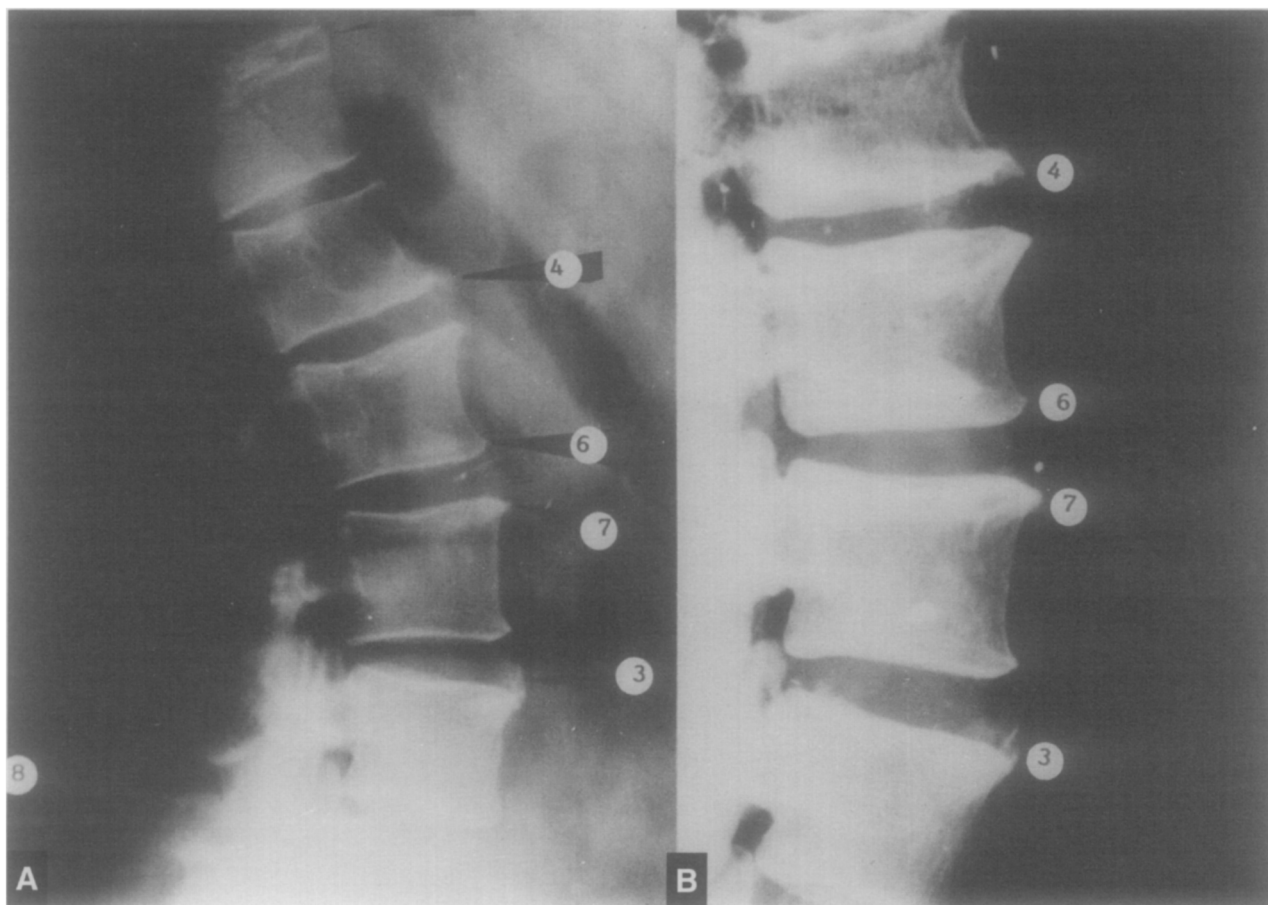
(A) Antemortem: radiograph of thoracic and lumbar spine showing age related morphological features. (B) Radiograph of torso found within the rubble in the 'AMIA' disaster, showing similar characteristics.
